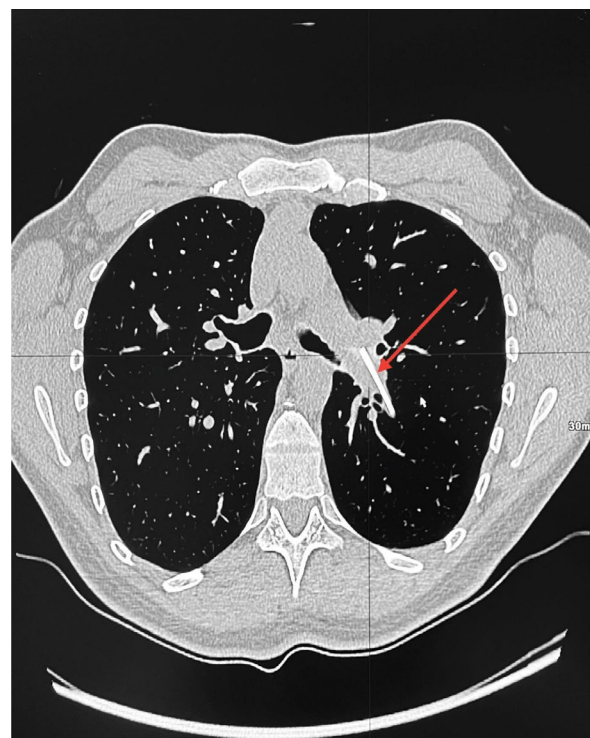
CT chest image showing migrated implant into the left pulmonary artery branch.
